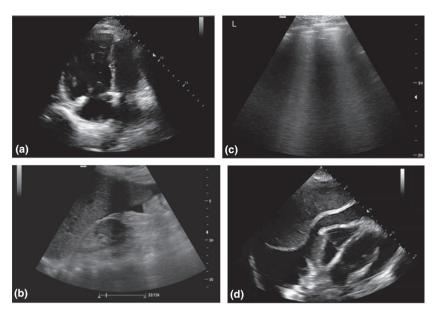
Examples of how ultrasound findings from the CPUS examination were used to help determine a leading diagnosis for patients with undifferentiated shock or respiratory distress. (a) Enlarged right ventricle imaged in apical four-chamber view. When seen with a distended, non-collapsing IVC in a patient with dyspnea, these findings are suggestive of a pulmonary embolism. (b) Free fluid in right upper quadrant. When seen with a hyperdynamic left ventricle and a flat IVC in a febrile patient with hypotension and abdominal pain, these findings are concerning for a sepsis, such as from typhoid fever. (c) B-lines imaged in bilateral lung fields. When seen with a hypodynamic left ventricle and a distended, non-collapsing IVC in a patient with hypotension and/or dyspnea, these findings are suggestive of decompensated systolic heart failure. (d) Pericardial effusion imaged in subxiphoid view. When seen with a distended, non-collapsing IVC in a patient with hypotension, these findings are concerning for cardiac tamponade.
